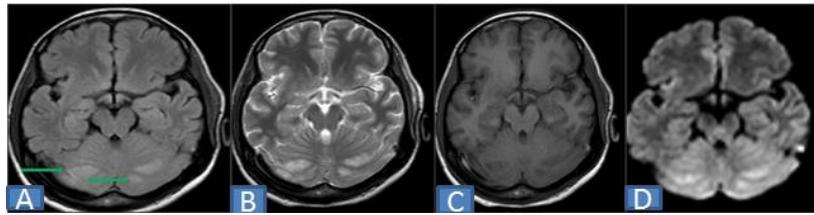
A case of Posterior Reversible encephalopathy Syndrome showing hyperintense lesions in bilateral cerebellar hemispheres (green arrow) on axial FLAIR (A) and T2WI (B) images , appearing hypointense on T1W images(C) and showing restriction of diffusion on DWI images (D).
